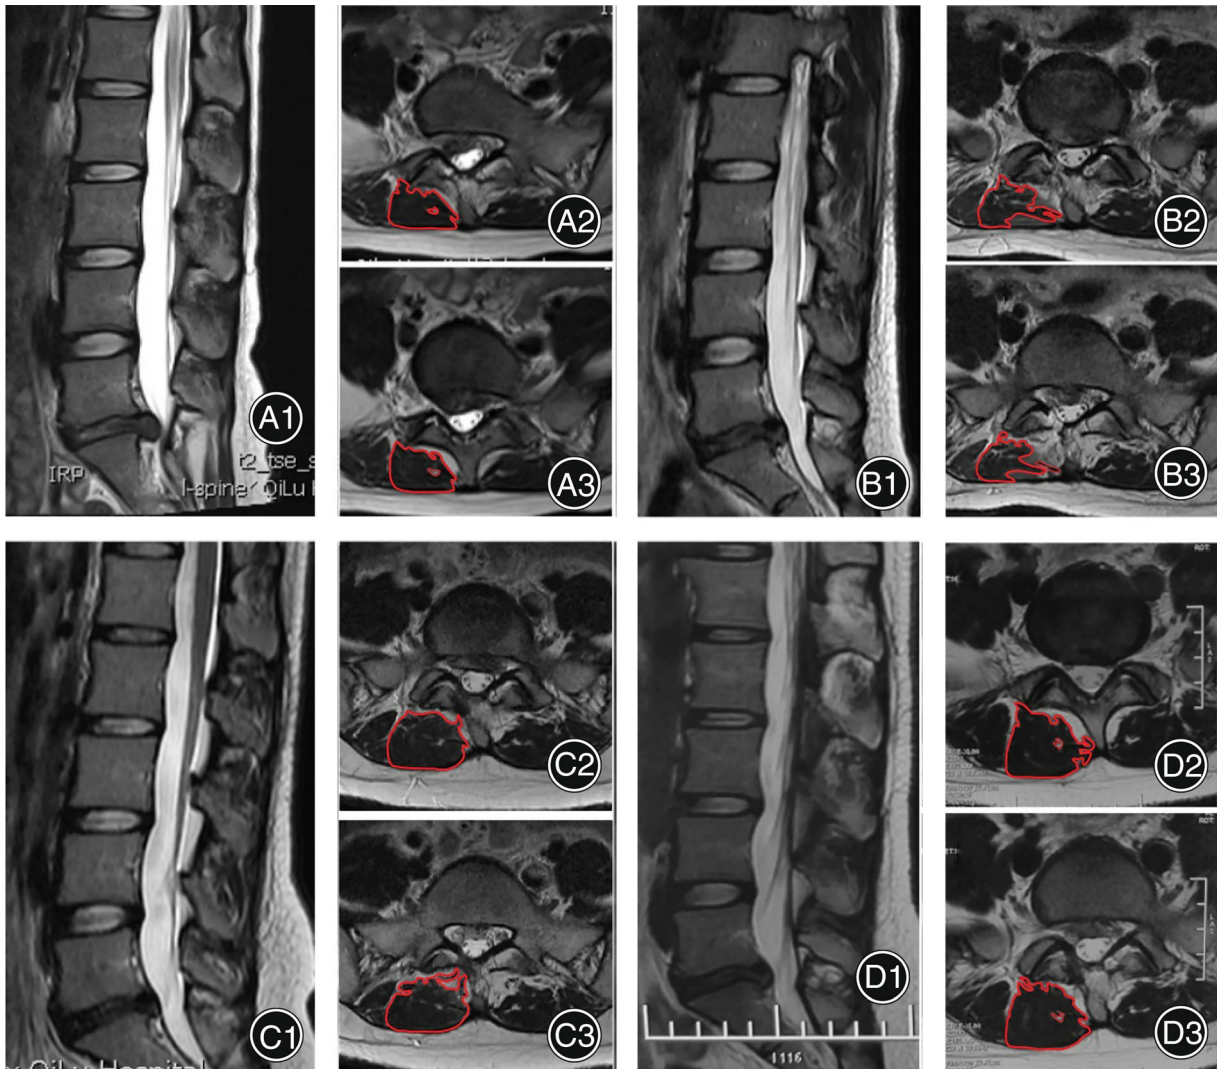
A 20-year-old female patient with LDH of L5/S1 right side, treated with PEID surgery. A1-A3 were the preoperative MRI. B1-B3 were the MRI of post-operative 1st day. C1-C3 were the MRI at the 3-month follow-up. D1-D3 were the MRI at the last follow-up of 1-year. The figures showed that the protruded disc of L5/S1 right side was removed after PEID surgery and the changes of LMCSA during the follow-up. The LMCSA was outlined on preoperative and postoperative MRI image. LDH, lumbar disc herniation; LMCSA, lean multifidus cross sectional area; MRI, magnetic resonance imaging; PEID, percutaneous endoscopic interlaminar discectomy.
